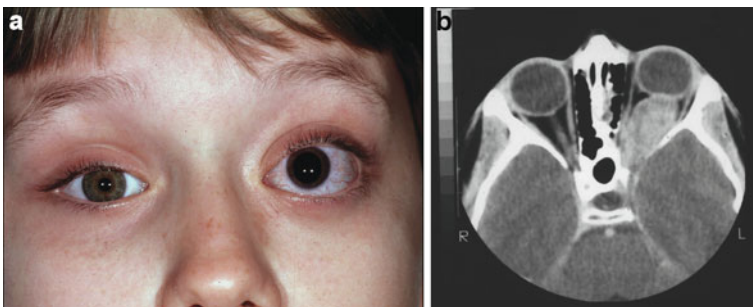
(a) Left optic nerve glioma in a child with neurofibromatosis type 1. (b) CT scan showing a fusiform lesion of the optic nerve extending from the globe to the orbital apex
